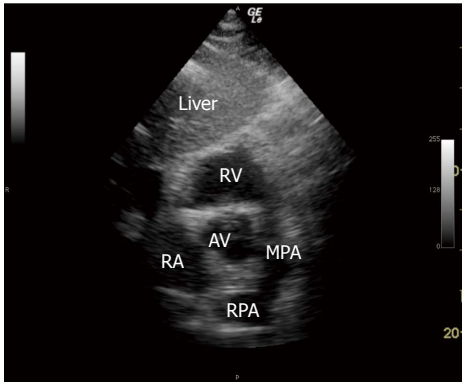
Subcostal right ventricular inflow outflow view, sonogram. RA: Right atrium; RV: Right ventricle; MPA: Main pulmonary artery; RPA: Right pulmonary artery; AV: Aortic valve.
